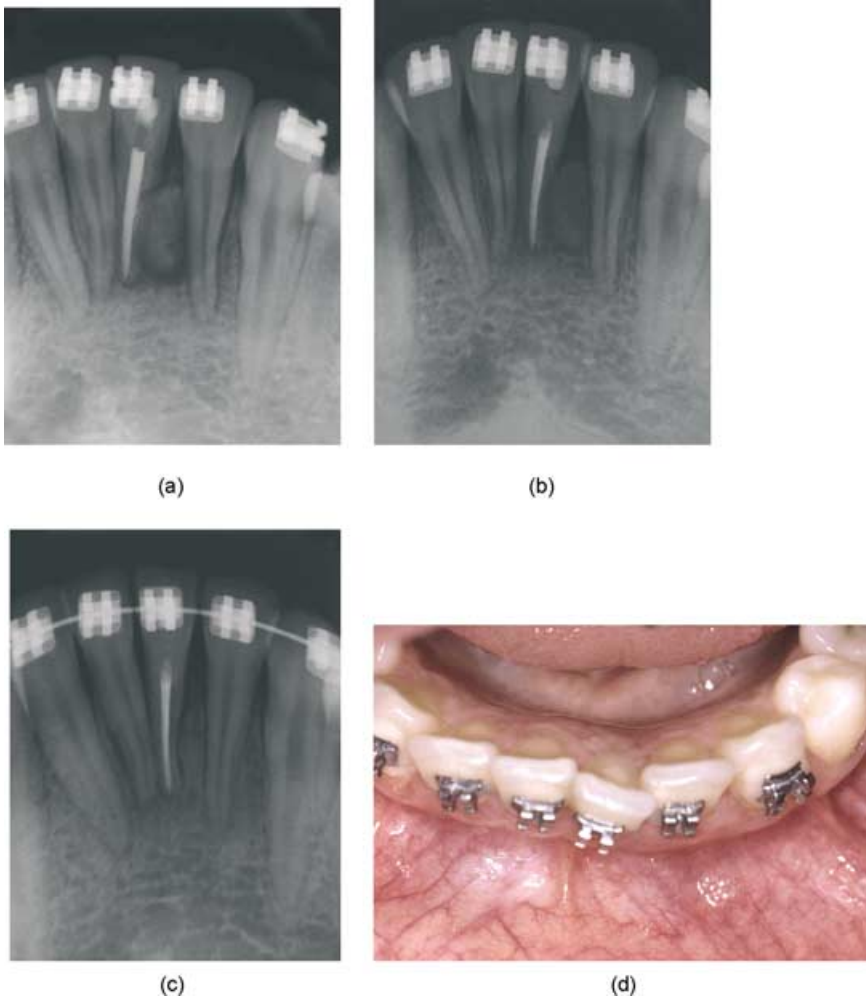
(a) Radiograph 1 month after curettage and bone graft; (b) radiograph after 4 months; note the incorporation of the bone graft; (c) radiograph after 2 years, with complete re-establishment of the lamina dura; (d) clinical aspect after 2 years.
